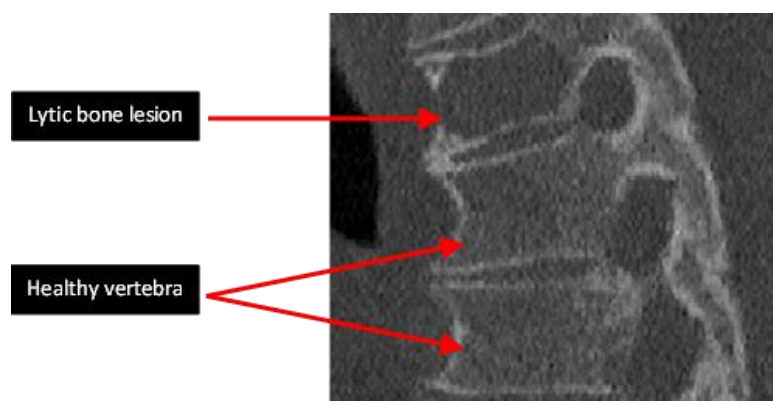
Zoom in of a CT scan of the spine showing three vertebra, one lytic (top) and two healthy (middle and bottom).
